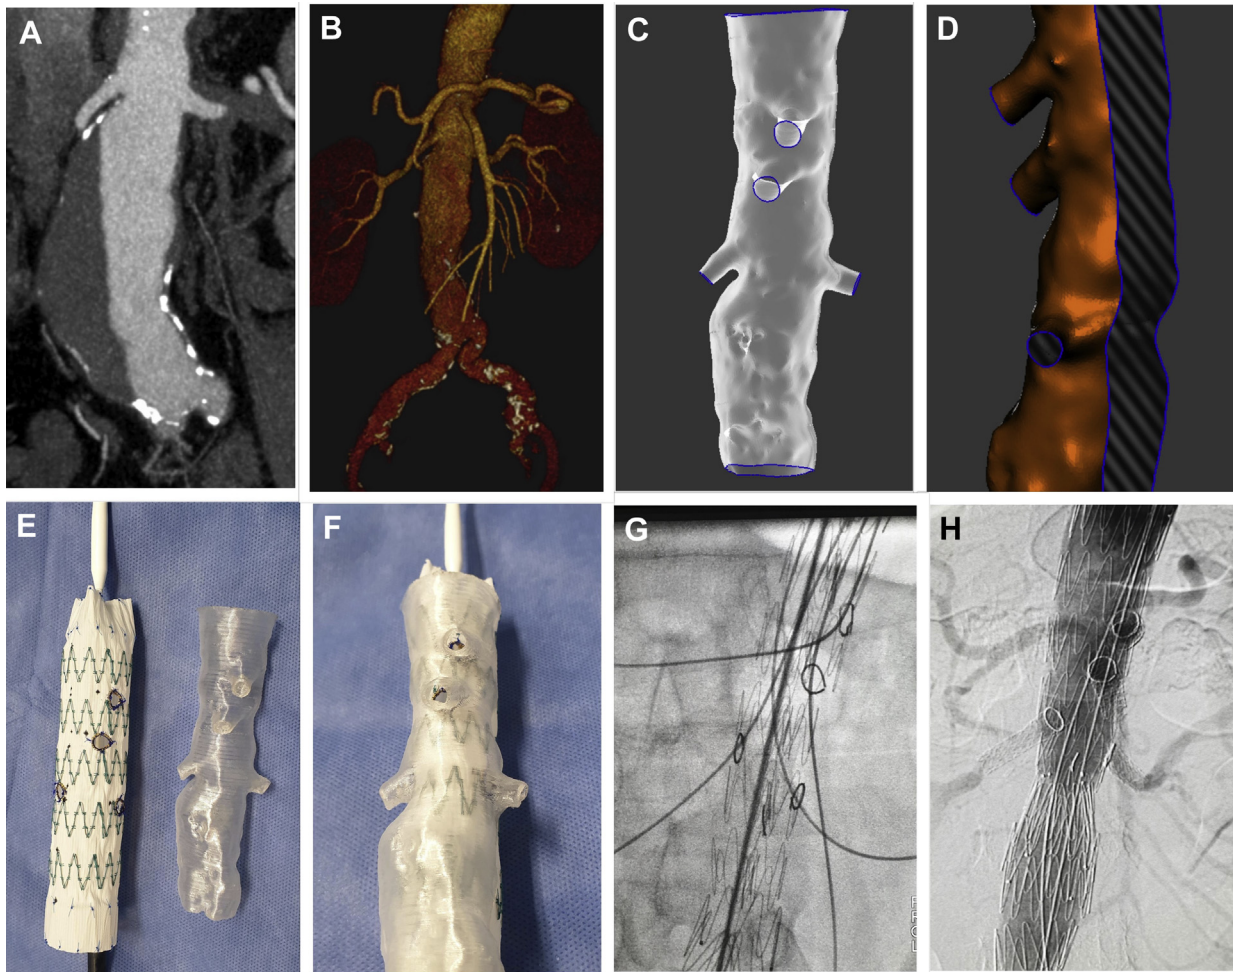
Case 2. A 77-year-old man with a symptomatic aortic aneurysm, unfit for open repair. Computed tomography (CT) scan reveals a juxtarenal aneurysm with suprarenal aorta and visceral and iliac arteries adequate for endovascular fenestrated repair (A and B). Three-dimensional (3D) hollow aortic model created with 3D Slicer and Meshmixer software (C) and aortic template file ready for printing (D). A Cook Zenith TX2 device was modified with the same technique, using the sterilized aortic model to place fenestrations accurately (E and F). Only 20 minutes was required to cannulate all four target vessels (G), and complete endovascular repair was finished with no complications and technical success (H).
